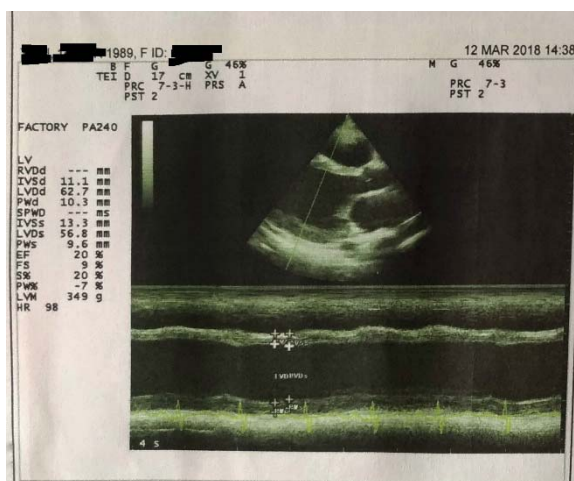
Echocardiogram finding on the patient
